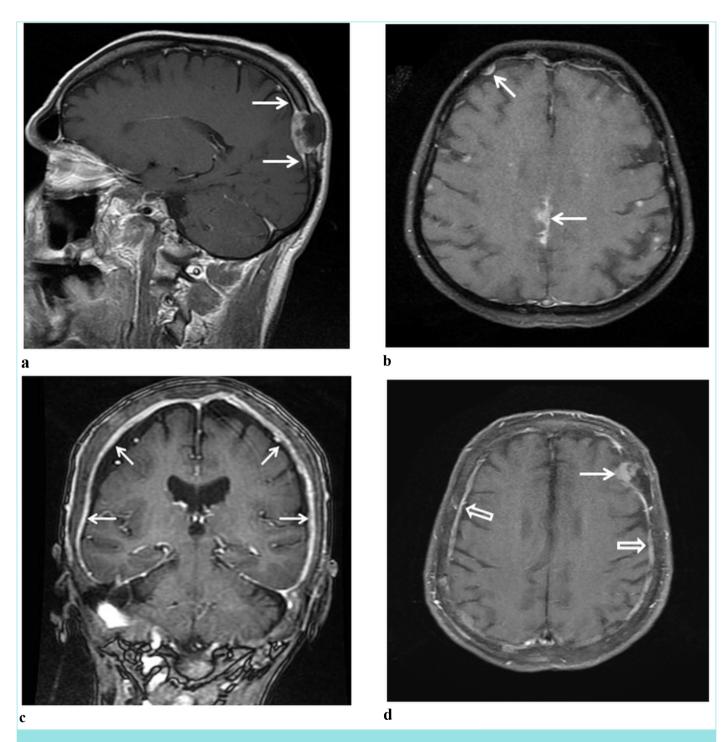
On contrast-enhanced T1-weighted magnetic resonance imaging, a) focal metastasis involving left occipital bone and adjacent dura and dural tail (white arrows) are shown. b) Multifocal cortical metastases are shown in right frontal and falcine dura and in cerebral parenchyma. c) Diffuse linear thickening and contrast-enhancing (arrows) due to tumoral involvement in dura are shown. d) Diffuse (open arrows) and nodular type (white arrows) dural thickening and enhancement with diffuse calvarial involvement are observed.
